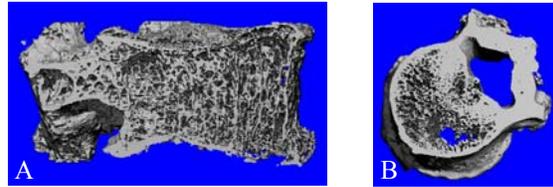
μ CT reconstructions of (A) MM vertebra and (B) BM vertebra
